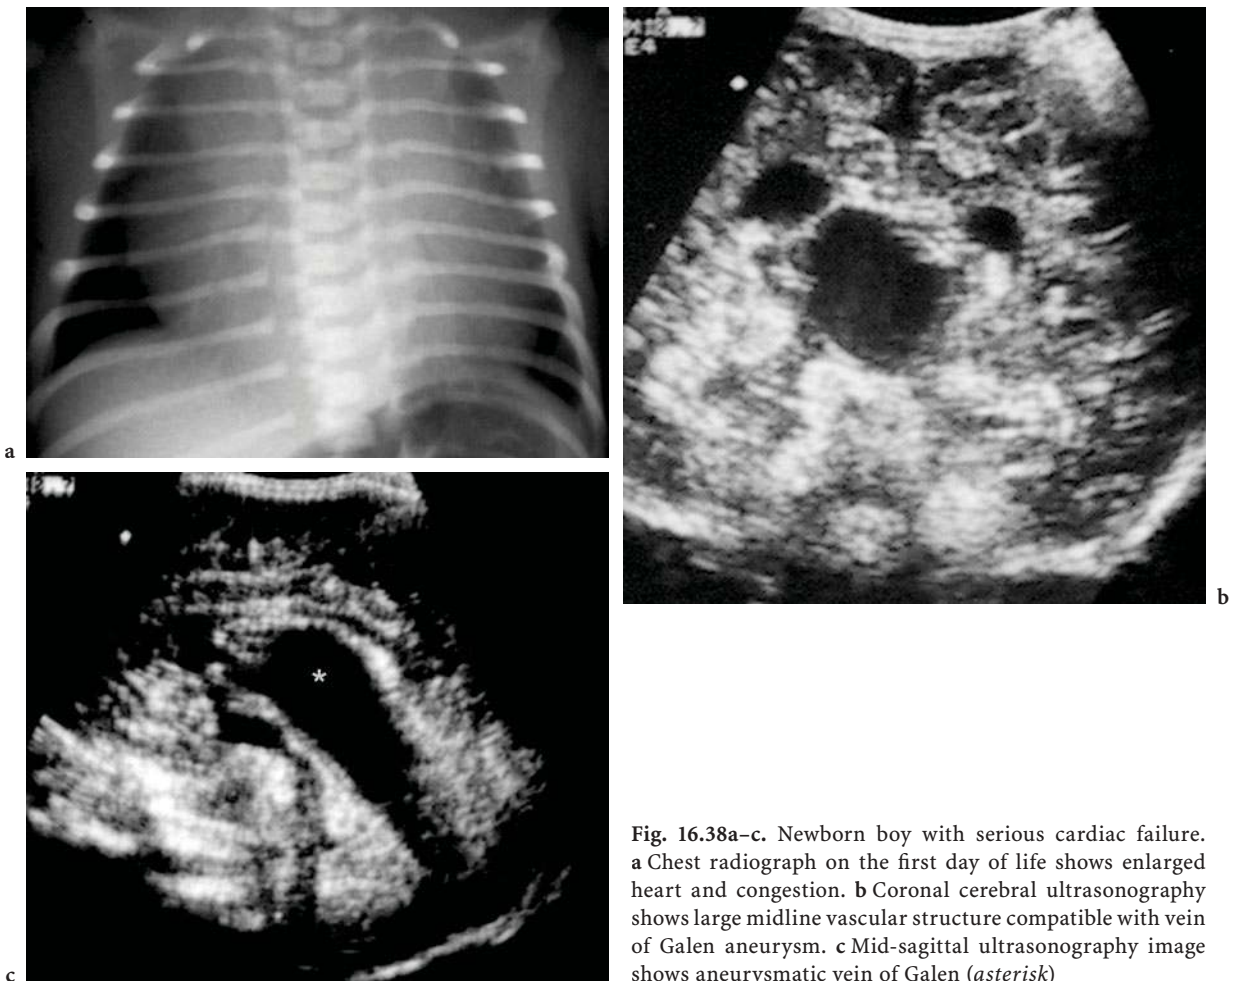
Newborn boy with serious cardiac failure. a Chest radiograph on the first day of life shows enlarged heart and congestion. b Coronal cerebral ultrasonography shows large midline vascular structure compatible with vein of Galen aneurysm. c Mid-sagittal ultrasonography image shows aneurysmatic vein of Galen (*asterisk*)
